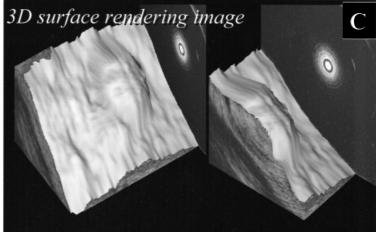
Three-dimensional imaging by the Olympus 3-D endoscopic ultrasonography system. (a) Helical scanning is achieved by automatic spiral withdrawal of the 3-D-endoscopic ultrasonography probe within its sheath for 1.5–4 cm (linear range). Serial radial image sections (40–120) are recorded at fixed intervals along the linear range. (b) A linear image is reconstructed from the serial radial image sections. A selected radial image and the linear image were displayed simultaneously as a dual-plane reconstruction image (DPR), which facilitates the assessment of tumor extent. T, tumor; short arrows point to the maximum infiltration depth (submucosa). (c) The recorded images are subsequently reconstructed into a 3-D view such as a surface-rendering image.
